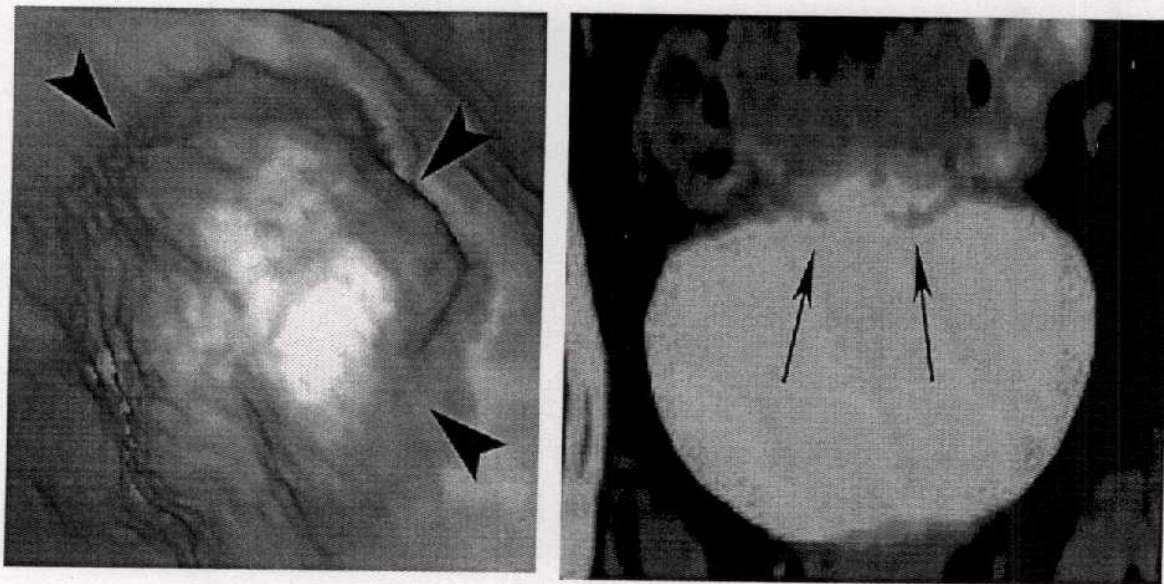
Relative thickness difference between the patient bladder and the atlas, measured by the Z score, indicates the region of abnormal thickness. (top left) Z score for one patient. (top right) Zoom in the CT scan for this patient. Similarly, the bottom row shows Z score and CT scan for a second patient. At the top of the first bladder, the Z score reveals a region of abnormal thickness (red). At the center of the second bladder, the Z score reveals two spots of abnormal thickness (red). (Jaume et al., 2003).
